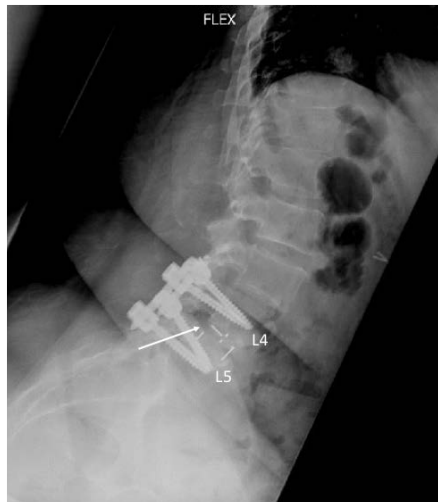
12-month post-operative dynamic, standing anteroposterior lumbar spine x-ray at L4-5. The residual PEEK cage is identified by the tantalum markers at L4-5. Posterior fixation is intact with no loosening of the screws. Bone fusion at L4-5 is indicated by the white arrow. The new bone growth is observed within and around the cage between L4 and L5.
